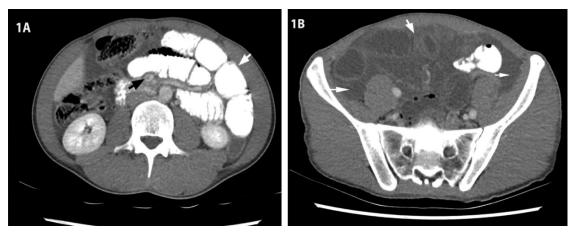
Abdominal CT scanning with intravenous contrast demonstrated suspicious filling defect in superior mesenteric vein (black arrow) and dilated small bowels with 35 mm in diameter (A), widespread free abdominal fluid (white arrow) (B).
